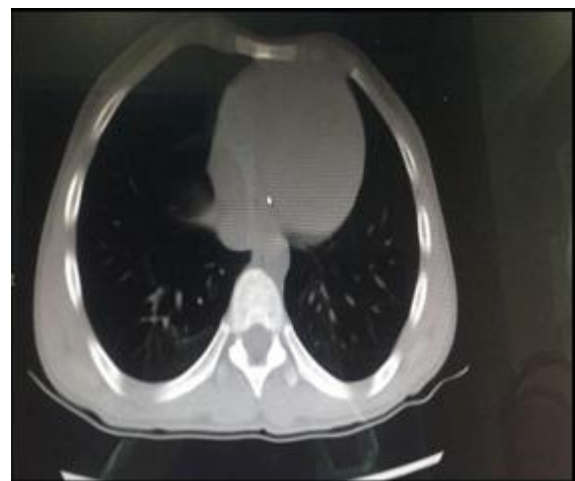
Patient CT-chest
